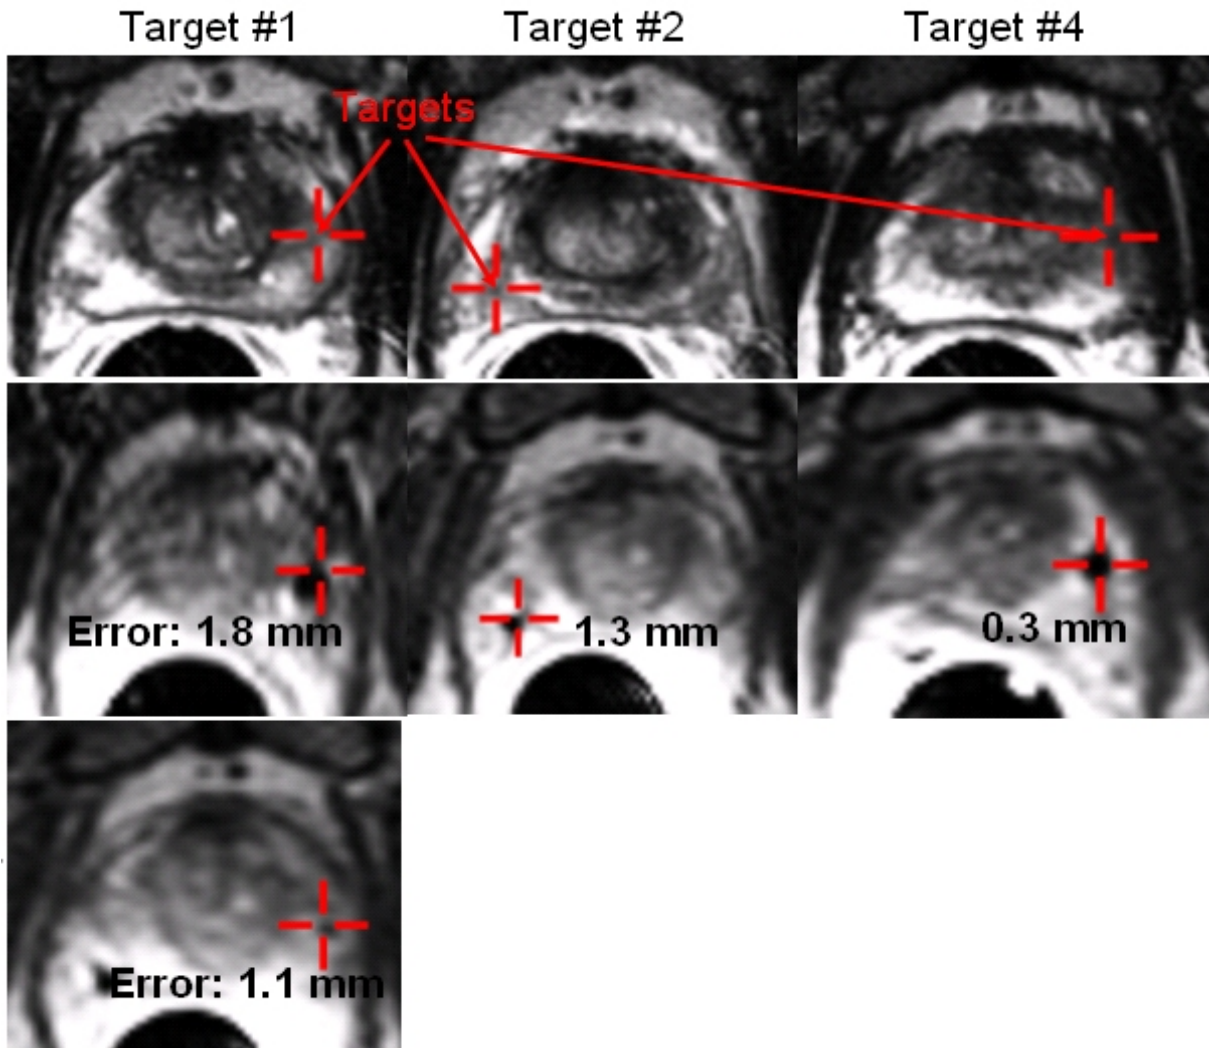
Targeting images, needle visualization images, and gold marker image of clinical procedure using the transrectal prostate intervention system. Top image row: Suspicious targets (red cross hairs) were selected on axial TSE T2-weighted images. Second image row: The needle tip void was visualized in axial TSE proton density images. The desired targets match the actual position of the needle. Error number: The number indicates the in-plane targeting error for the needle placement. Third image row: Axial TSE proton density image showing the location of the marker placed at target location number 1. The marker void is visible close to the target.
